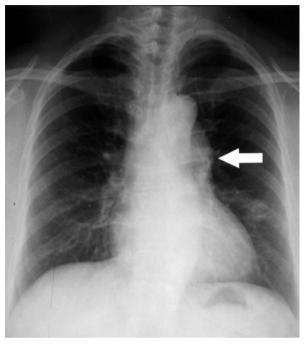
Chest roentgenogram showed a lesion on the left mediastinum without lung parenchymal lesions (*arrow*).
